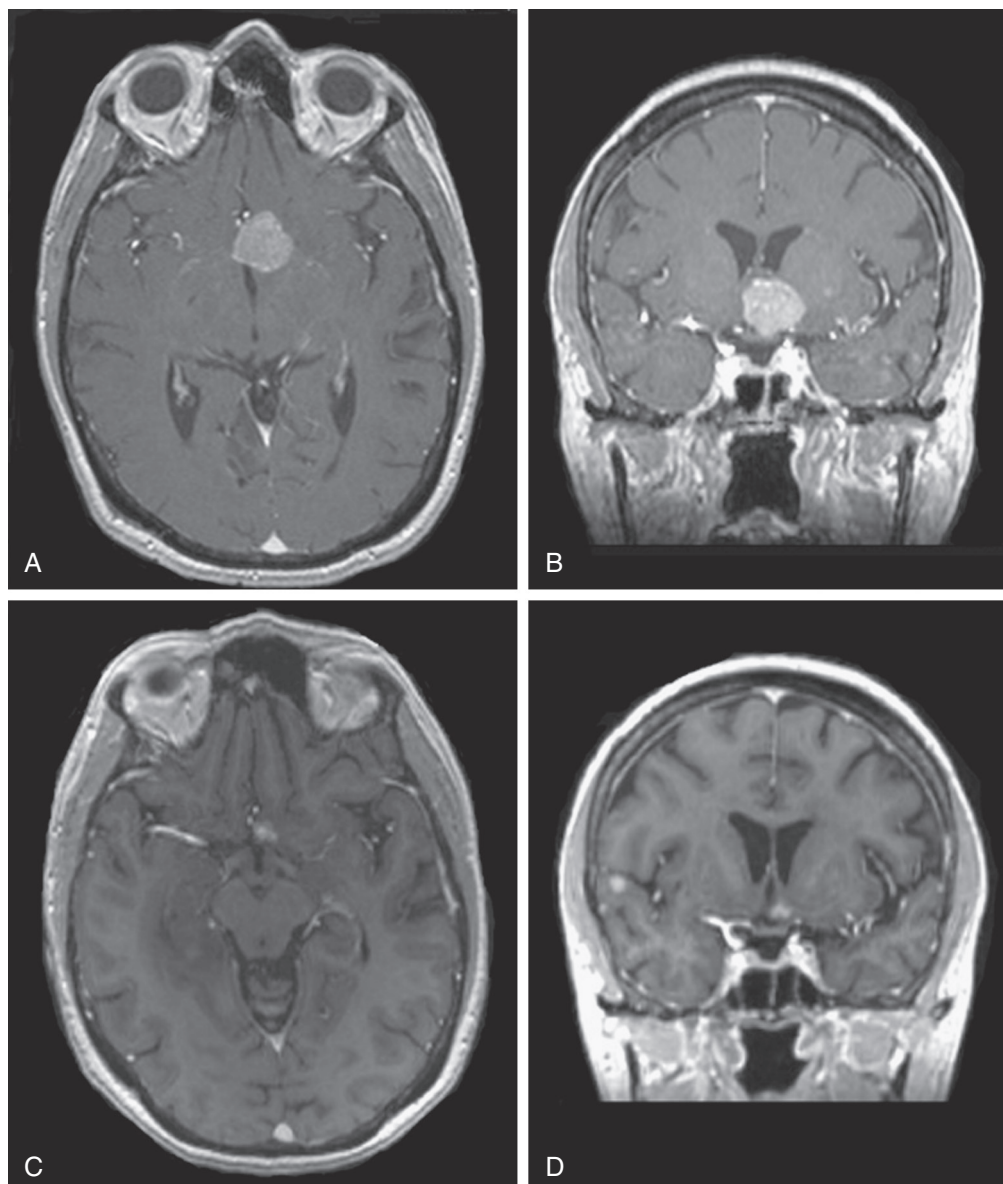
The patient is a 54-year-old woman with a history of metastatic non–small cell lung cancer. She underwent stereotactic radiosurgery (SRS) to treat a left perioptic brain metastasis. The tumor was treated in a single session with a margin dose of 16 Gy and a maximum point dose to the optic pathway of 12 Gy. The metastatic lesion is shown on the pre-SRS postcontrast axial (A) and coronal (B) magnetic resonance imaging (MRI). Six months later, the patient's visual fields and acuity were stable. Her tumor had markedly regressed as demonstrated by the follow up postcontrast axial (C) and coronal (D) MRIs. Of note, D shows a new metastatic lesion in the right Sylvian fissure region that was later treated with SRS.
